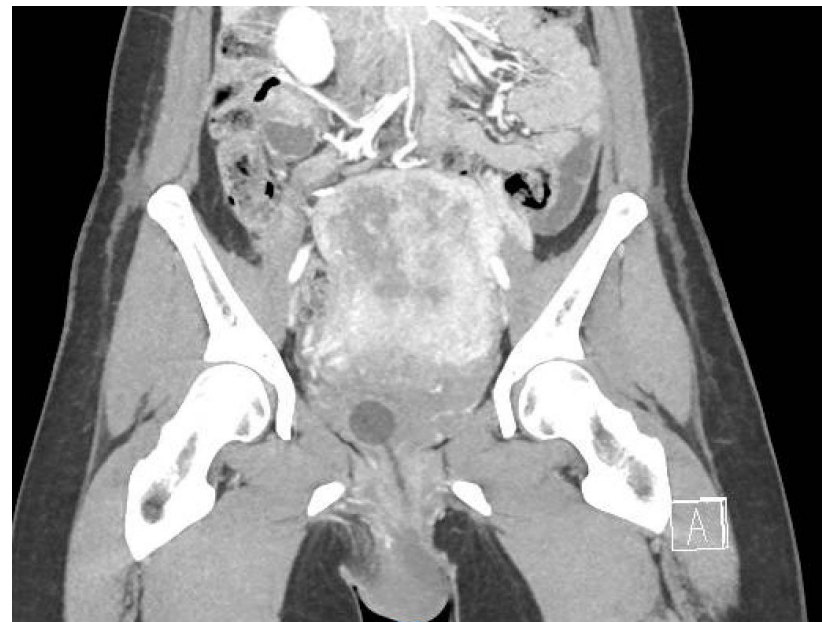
Figure One: CT images showing 12 x 5 x 5 cm bladder flap haematoma (green arrow) and right vulval haematoma (yellow arrow) without features of active arterial bleeding at time of scan.
